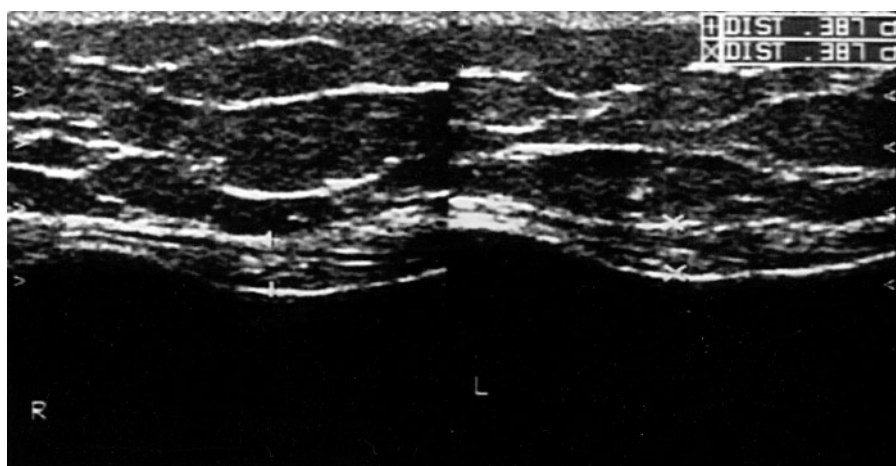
Longitudinal sonographic imaging of the PA tendons in a patient with type 2 DM. Thickness and fibrillar echotexture of the tendons were similar in both knees.
